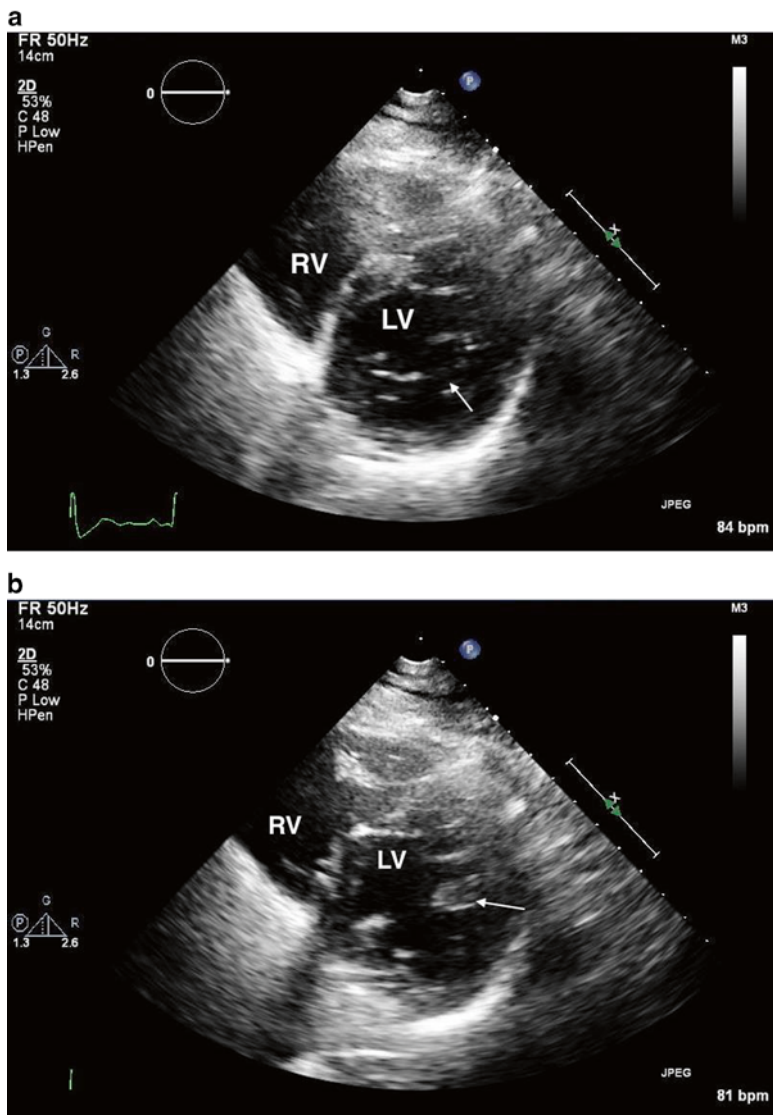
Parasternal short axis views. Multiple short axis images through the right and left ventricles are obtained from the base of the heart (atrioventricular (AV) valve level) to the apex. (a) Base of the ventricles: The anterior and posterior mitral valve leaflets are seen in cross section (*arrow*). The right ventricle (RV) is anterior and on the right, the left ventricle (LV) is posterior and on the left. (b) Mid-ventricular level: The bodies of the anterolateral and posteromedial papillary muscles are visualized in cross section (*arrow*). (c) Apex: The apex of the right (RV) and left (LV) ventricles are displayed in cross section. The heads of the papillary muscle heads are not included in this view
